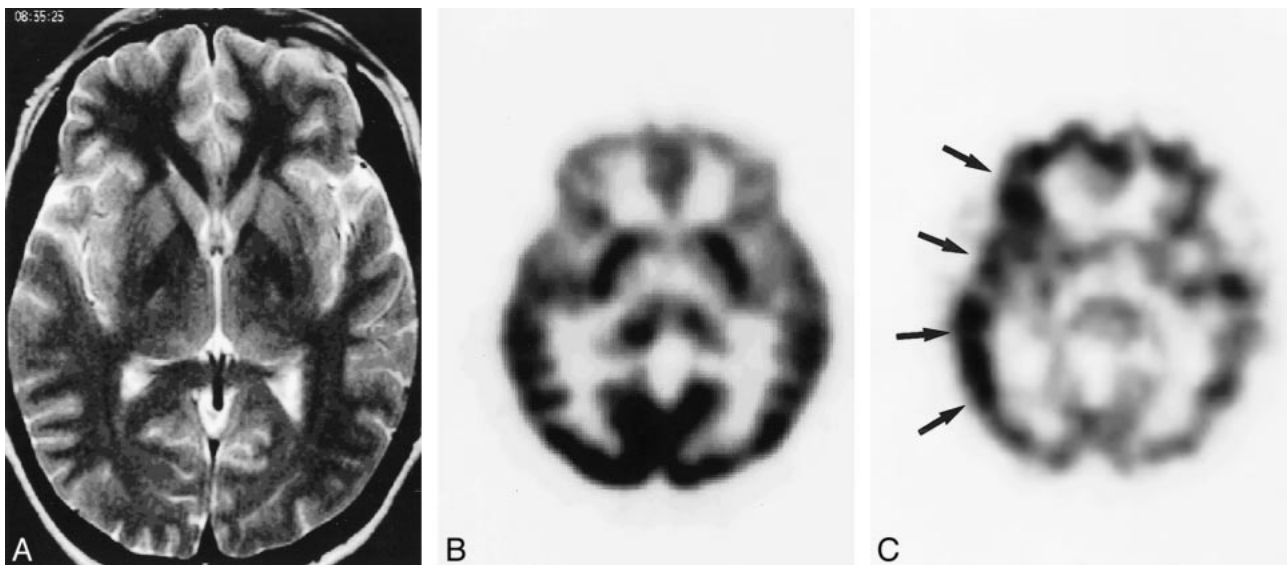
False-negative MR imaging and PET findings for a 25-year-old woman with right neocortical temporal lobe epilepsy. A, Axial fast spin-echo T2-weighted (6000/90) MR image shows no focal abnormalities. B, Axial FDG PET scan shows no focal abnormalities. C, Ictal SPECT scan shows somewhat diffuse hyperperfusion in the right frontotemporal cortices (arrows). Invasive EEG study detected ictal activity arising from the right temporoparietal area. After neocortical resection, the pathologic diagnosis was heterotopia. Engel's outcome was class I.
